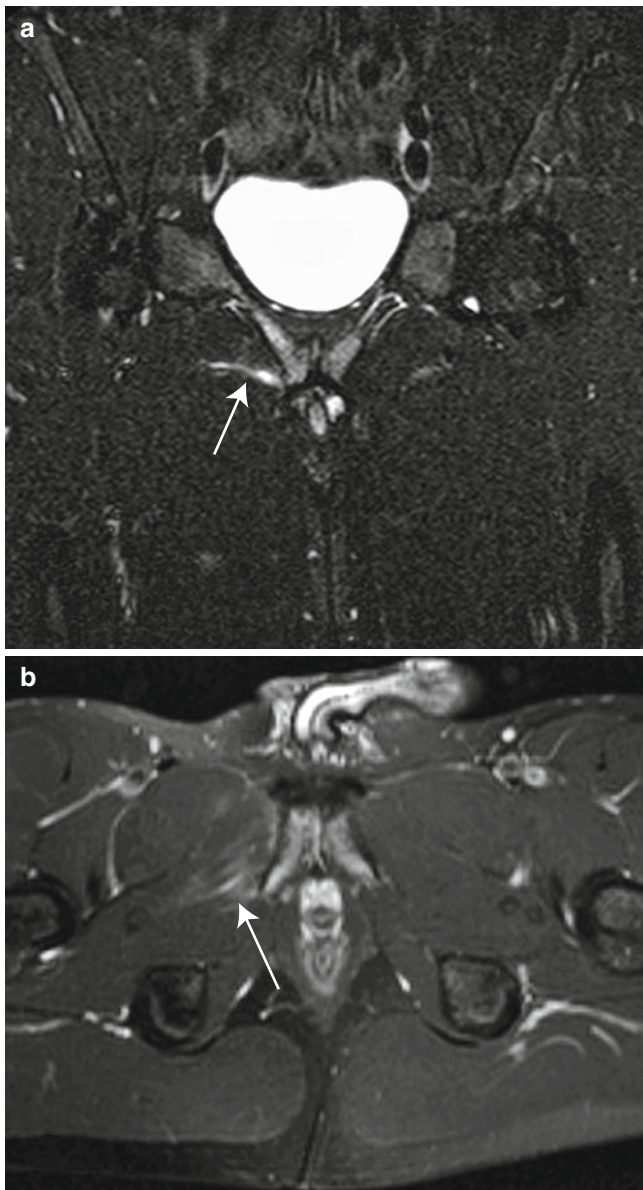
Coronal (a) and axial (b) MR images from a hockey player show streaky edema following the distribution of the right obturator externus (*arrows*)
